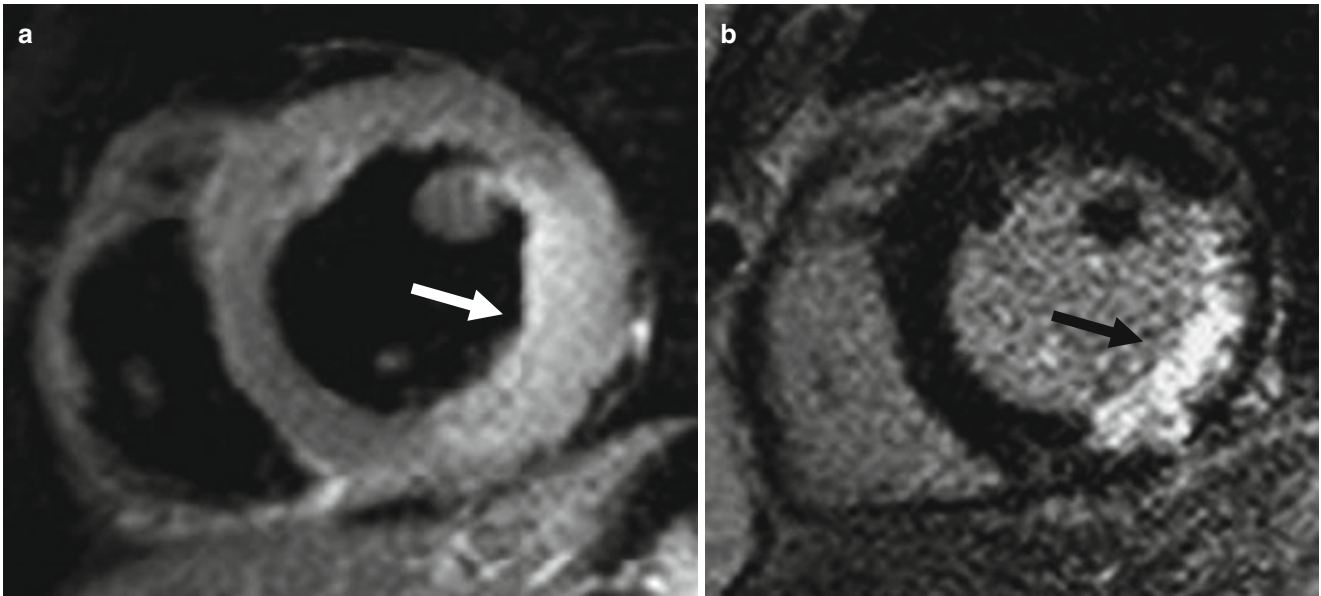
The role of T2WI in differential diagnosis of acute and chronic MI (acute MI: 5 days ago). T2 MRI (a) shows high-signal area at inferior and inferolateral wall with swelling (*arrow*). LGE (b) also shows hyperenhancement at the same area (*arrow*)
